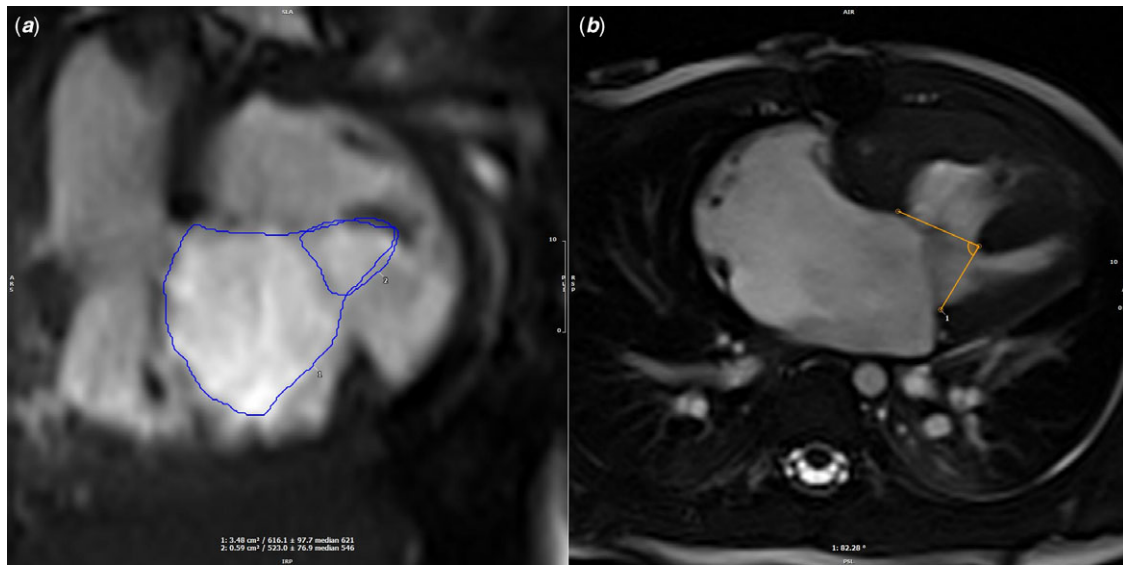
Example CMR measurements. a. Left and total AV valve area measured from a short-axis view. b. LV–RV angle in diastole measured from four-chamber view. AV = atrioventricular; CMR = cardiac MRI; LV = left ventricle; RV = right ventricle.
